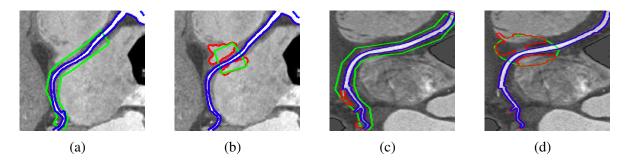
Performance of two segmentation methods for clinical images. (a) and (b) show right coronary of CTA volume 01 for two different initialization. (c) and (d) show right coronary of CTA volume 02 for two different initializations. Green denotes the initialization, whereas blue and red represent the hybrid and localized segmentation, respectively. The localization radius used for these results is 8 pixels.
